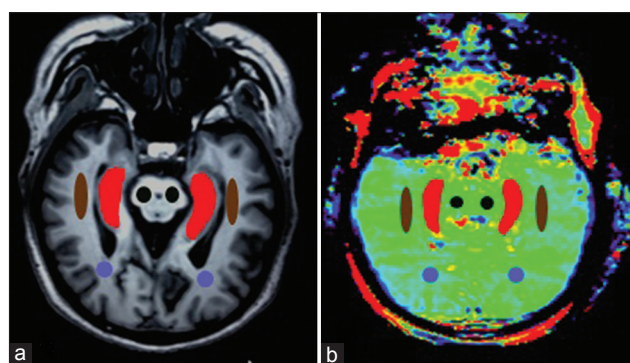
T1-weighted image (a) and amide proton transfer image (b) were oblique axial planes along the long axis the hippocampi (Hc). Examples of the definition of the regions of interest for quantitative analysis (Brown: Temporal white matter; Purple: Occipital white matter; Black: Cerebral peduncle; Red: Hc).
